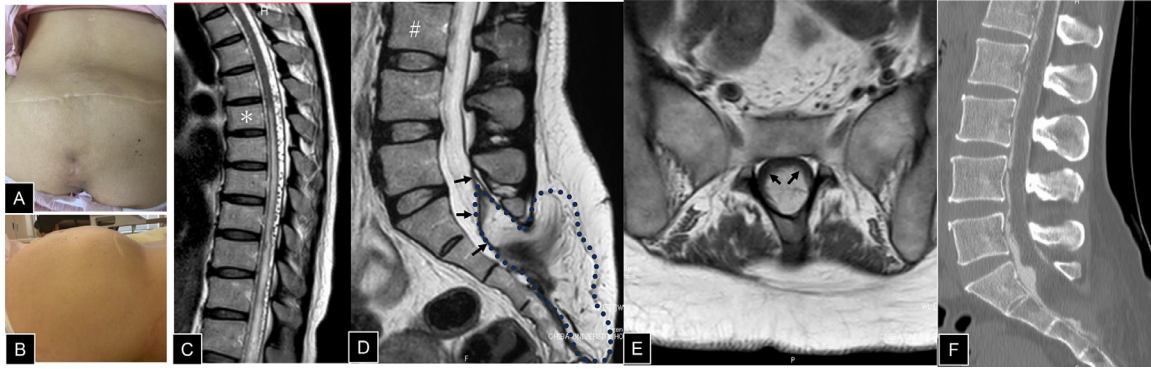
(A, B) Superficial image of her buttocks show surgical scar and a sacral dimple. (C, D) T2WI of spinal MR imaging reveal intramedullary high-intensity signal changes from the level of the sixth thoracic vertebra to conus medullaris as well as a flow void around the spinal cord. Arrows indicates the area of continuity of spinal cord to the spinal lipoma. Dots indicate the periphery of spinal lipoma. *,# Represent sixth thoracic vertebra and third lumbar vertebra, respectively. (E) Axial image of T1WI of MR imaging shows a flattened spinal cord with smooth borderline (black arrows). (F) A contiguous spinal cord and spinal lipoma is seen on CT myelography.
